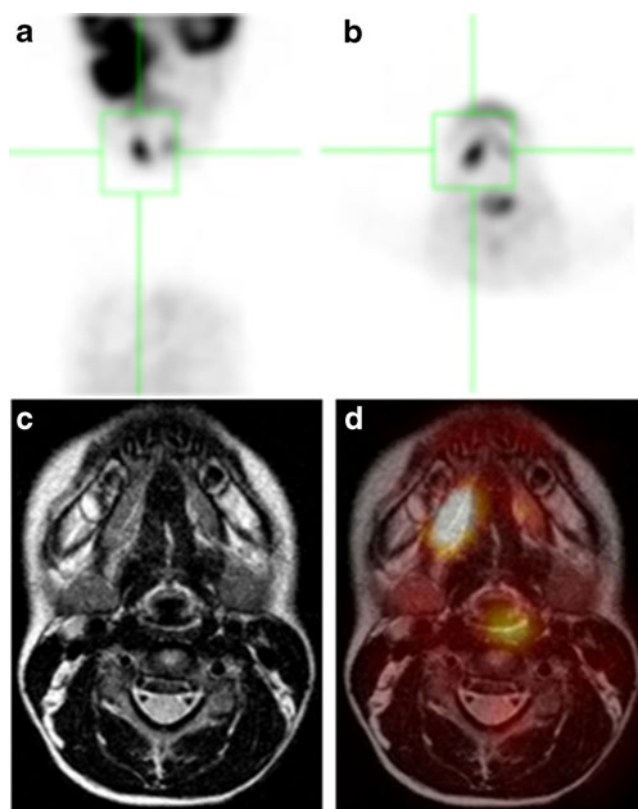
A 5.5-year-old girl with rhabdomyosarcoma—false-positive on ¹⁸F-FDG PET. At primary diagnosis, ¹⁸F-FDG PET (a, b) shows an increased uptake in the submandibular region; a lymph node metastasis of the rhabdomyosarcoma was suspected. On the MRI (c T2-weighted sequence, d image fusion), no morphological changes are seen in this location. Therefore, the uptake corresponds to physiological muscle activity. During follow-up, the lesions disappeared on ¹⁸F-FDG PET. The retromandibular primary tumour with its growth through the skull base is seen on ¹⁸F-FDG PET (a)
